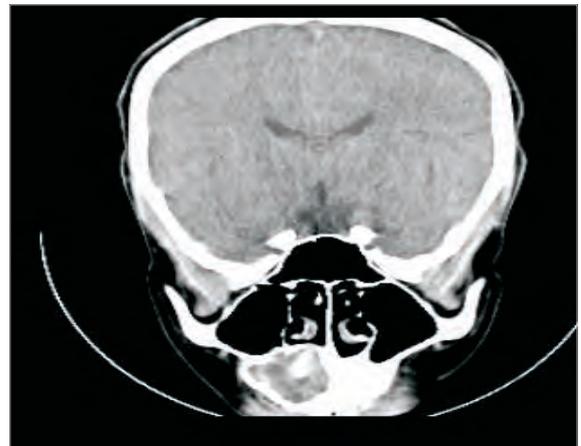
Coronal CT Showing Tooth Highlighted in dentigerous Cyst
